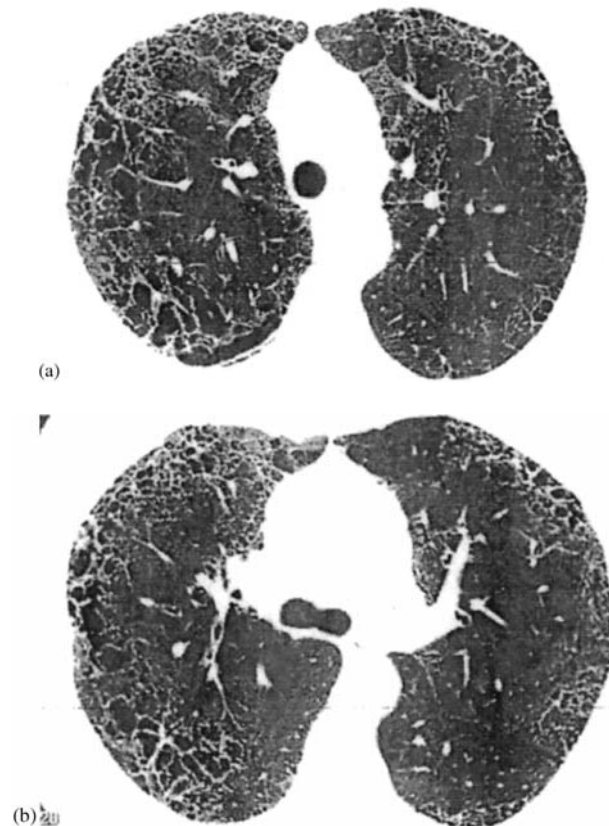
(a) UIP. HRCT (upper lobes) demonstrates peripheral honeycomb change and thickened interlobular septa. No significant GGO are present. (b) UIP. HRCT from the same patient at level of the carina. Peripheral honeycomb change, thickened interlobular septa, and a reticular pattern are evident.
